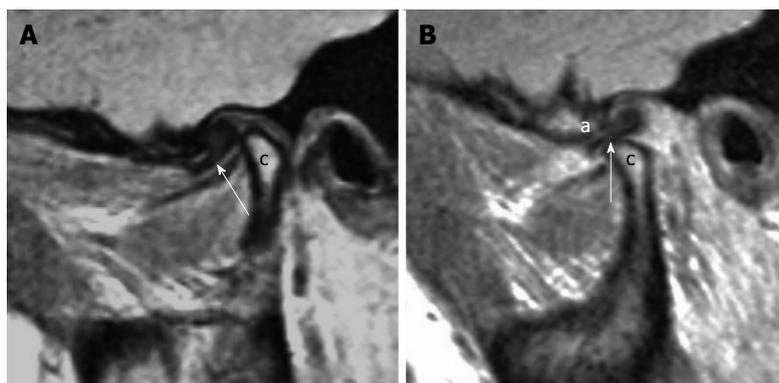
Anterior displacement with reduction. A: Sagittal proton density weighted magnetic resonance imaging (MRI) in the closed mouth position demonstrates anterior displacement of the disk (arrow) in front of the mandibular condyle (the letter, c); B: Sagittal proton density weighted MRI in the open mouth position demonstrates reduction of the disk (arrow) between the articular eminence (the letter, a) and the mandibular condyle (the letter, c).
